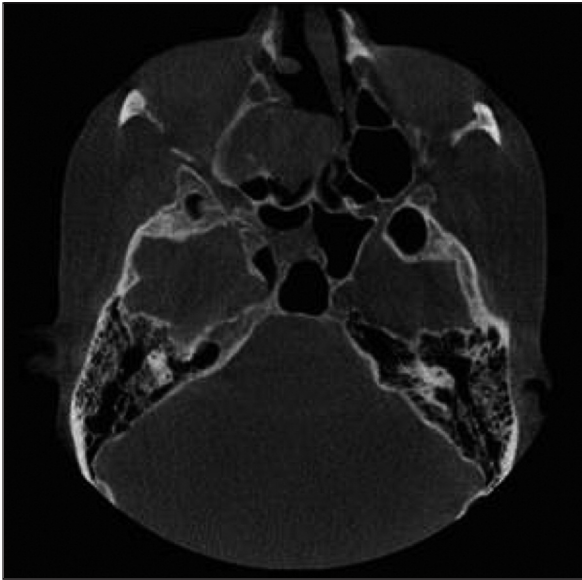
Axial section on cone beam computed tomography showing lesion medially invaded into the right nasal cavity, ethmoid sinuses.
